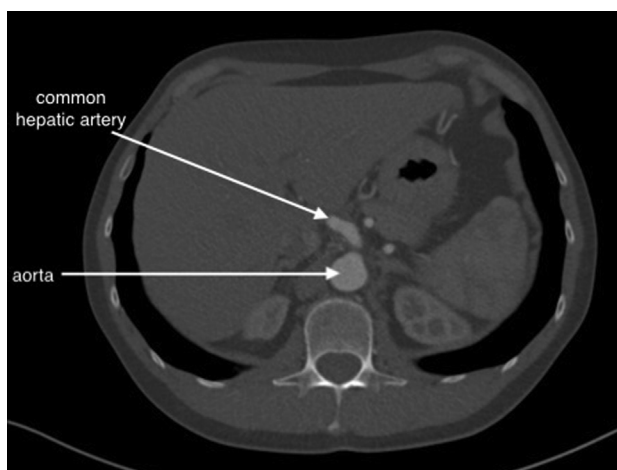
Follow-up computed tomography angiogram.
